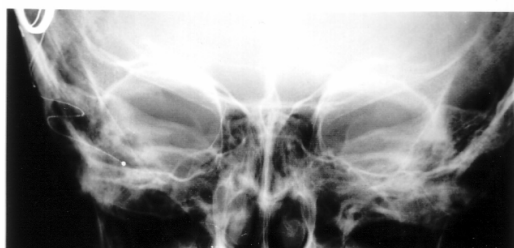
Post operative periorbital skull x-ray of the patient showing position of the single channel extracochlear ball electrode.
